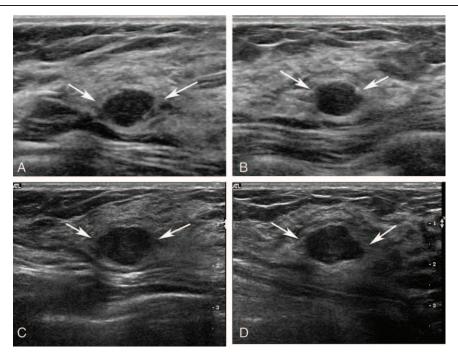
Breast ultrasound images for a 63-year-old woman with an invasive ductal carcinoma. Transverse (A) and longitudinal (B) ultrasound images show a hypoechoic solid mass (arrows) with an oval shape and angulated margin in the right breast. The mass was initially categorized as a probably benign lesion. After 6 months, the mass (arrows) showed an increase in diameter from  $12 \times 10 \times 14$  to  $22 \times 14 \times 19$  mm (C, longitudinal image; D, Doppler image). Ultrasound-guided core-needle biopsy was performed and invasive ductal carcinoma was diagnosed. The greatest diameter change, diameter change per month, diameter change per initial diameter per month were 10 mm, 1.7 mm, 82.0%, and 13.9%.
